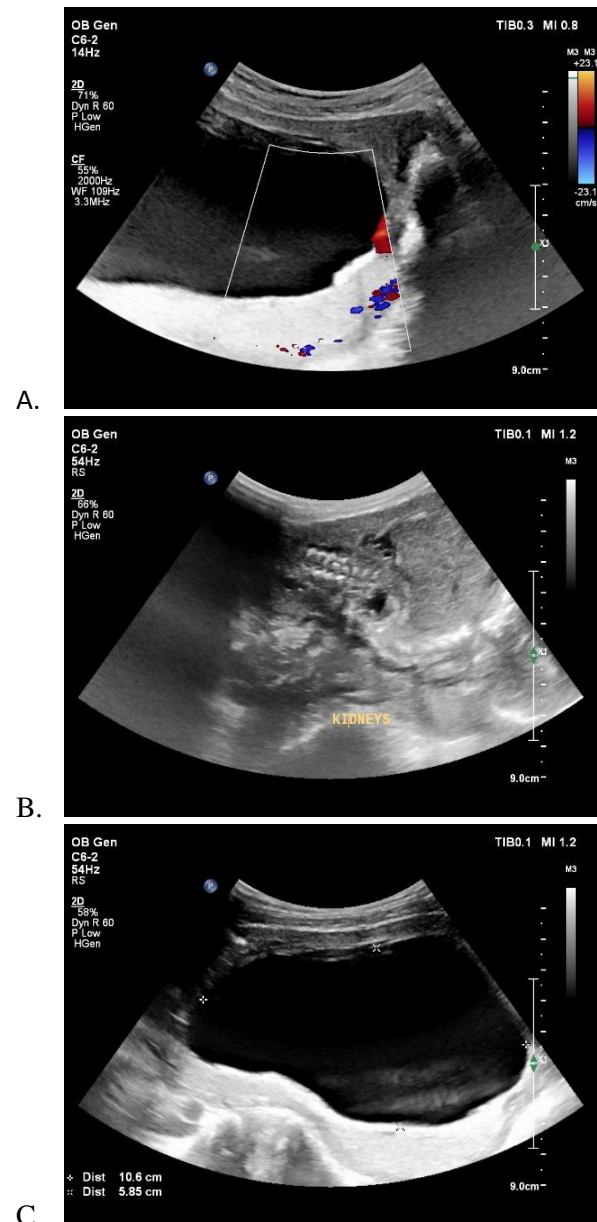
A : Color doppler image showing single umbilical artery B : Grey scale image showing well defined cystic lesion in the abdominal cavity. C: Grey scale image showing bilateral hydronephrosis.
